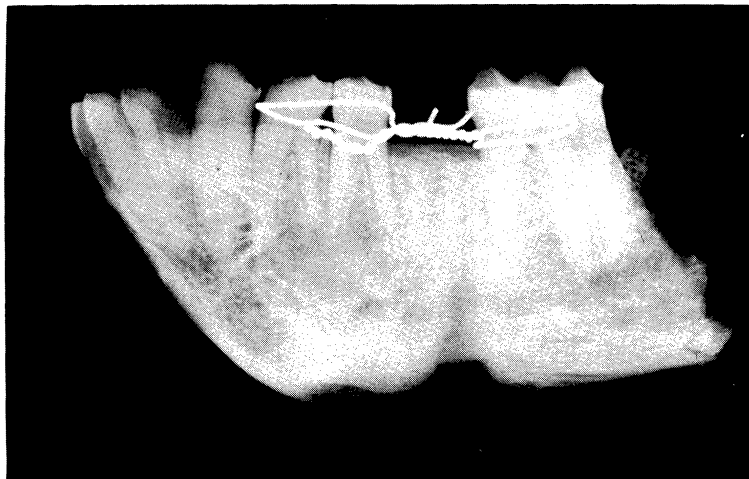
Lateral jaw X-ray twelve weeks following body fracture into which the cyanoacrylate monomer was incorporated.
